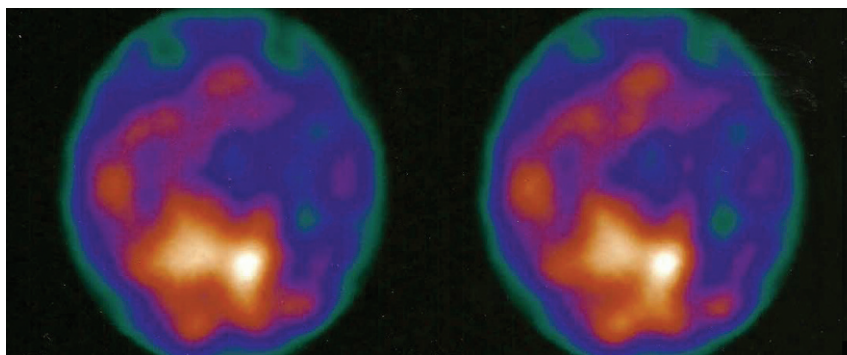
SPECT (sequence of axial slices) showing left frontotemporal focal hypoperfusion.
